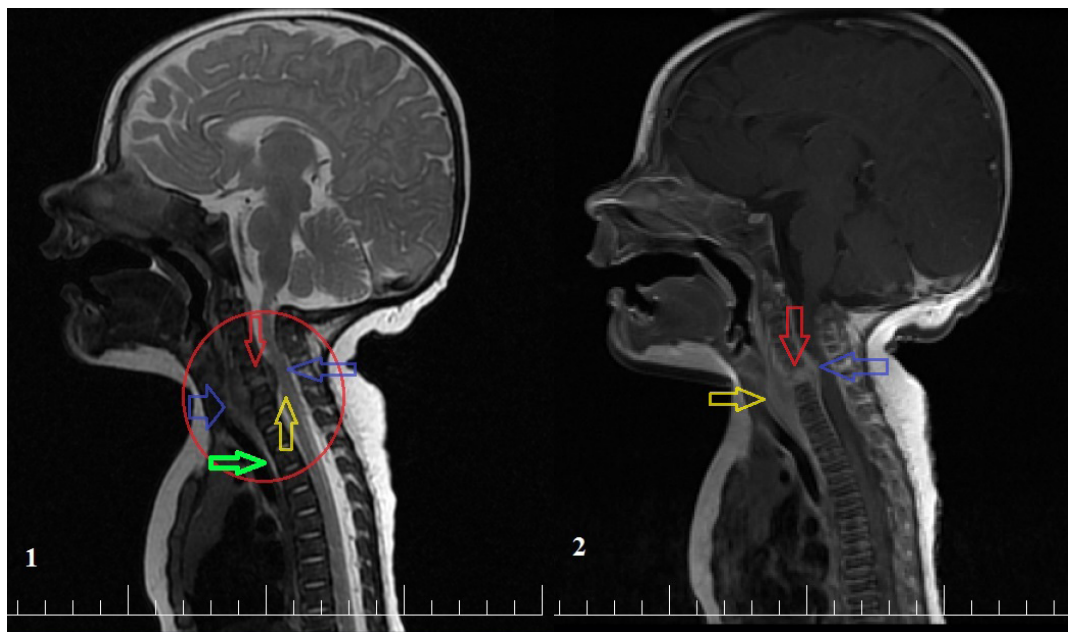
T2-weighted sagittal MRI of cervical and thoracic spine - showing high signal at the level of cervical vertebral body (red circle) especially at C5 and C6 and of the intervertebral disc (red arrow) with paravertebral and epidural collections (blue arrows). This structure compresses the spinal cord (yellow arrow). The dangerous space is widened too (green arrow).
